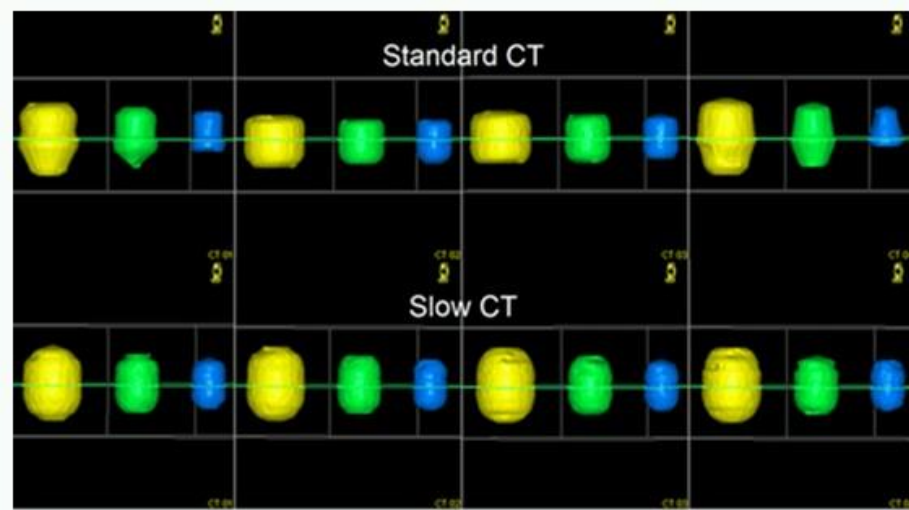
Comparison between Standard and Slow CT in peak-to-trough motion of 1.5 cm for 4 images ⁽²⁷⁾
